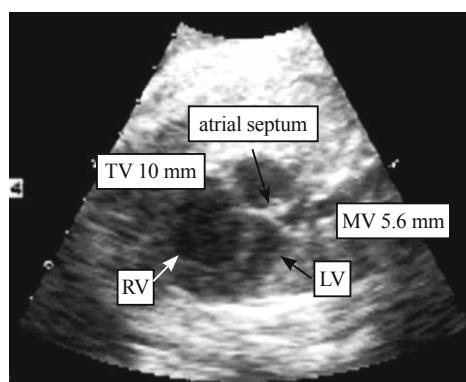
Fetal echocardiogram taken one day before delivery indicated diminished cavity volume of the left ventricle with a small mitral valve annulus. The atrial septum looked thick and closed. TV: tricuspid valve; RV: right ventricle; MV: mitral valve; LV: left ventricle.
